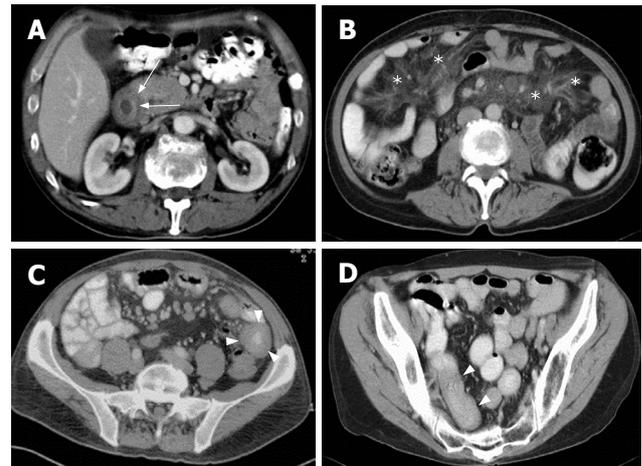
Axial CT images demonstrating locations of EATL. A: Duodenal localization of lymphoma (arrow); B: Mesenteric localization showing "misty mesenterium" (*) and multiple lymph nodes; C: Jejunal localization of lymphoma (arrowhead) and multiple lymph nodes; D: Ileal localization (arrowhead).
